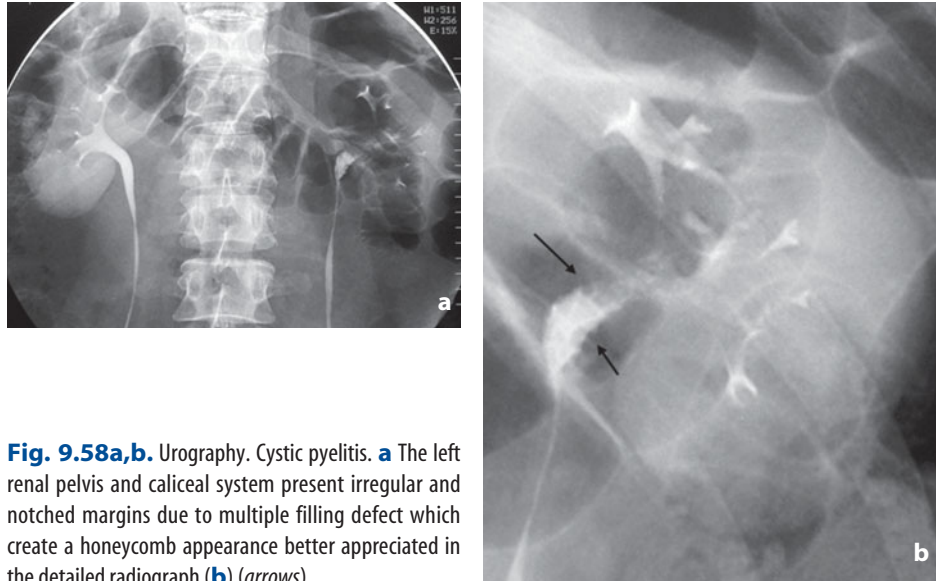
Urography. Cystic pyelitis. a The left renal pelvis and caliceal system present irregular and notched margins due to multiple filling defect which create a honeycomb appearance better appreciated in the detailed radiograph (b) (arrows)
